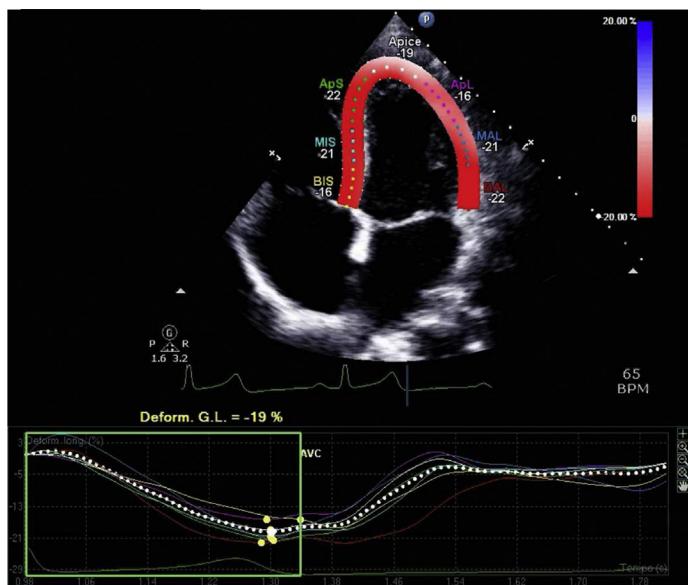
Example of LV longitudinal strain measurement from the apical 4-chamber view. AVC, aortic valve closure; G.L., global longitudinal strain.
